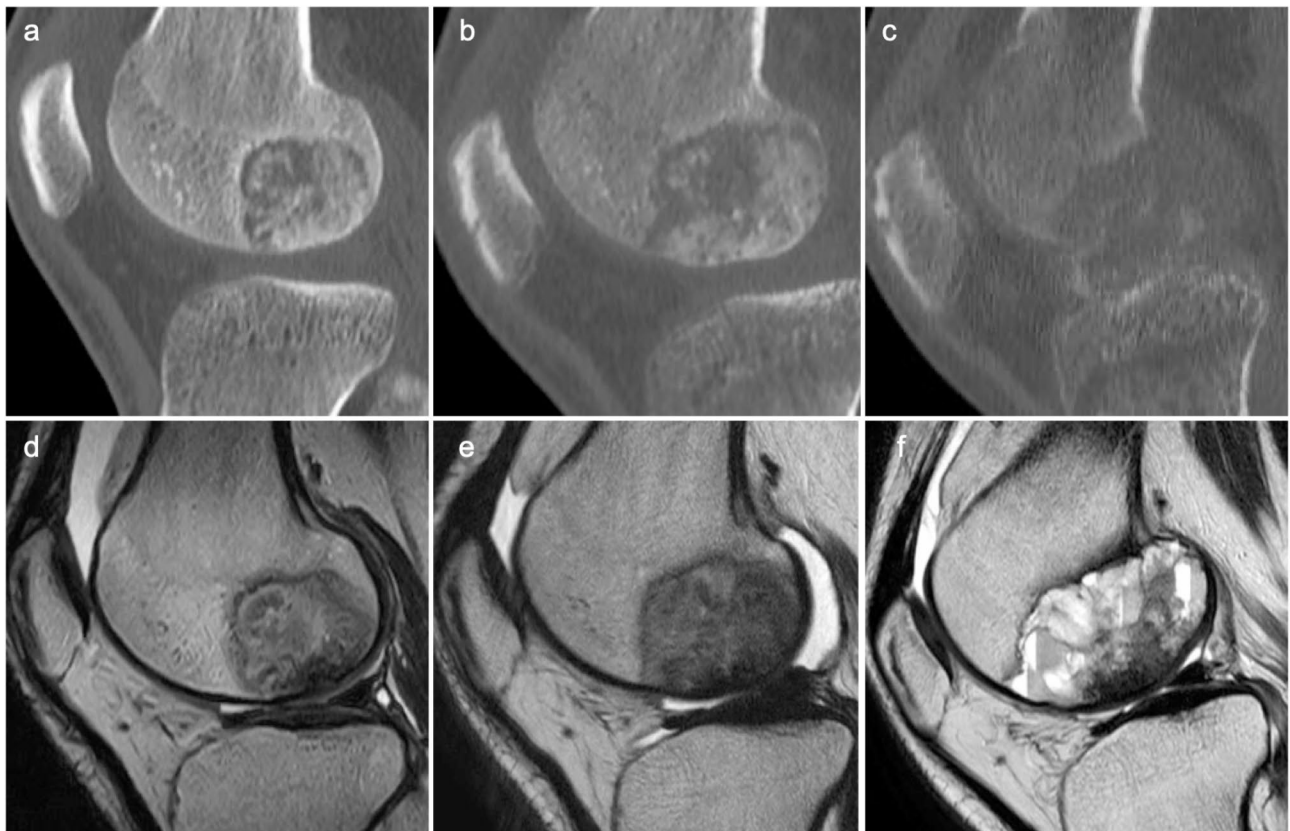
Longitudinal changes in CT and MRI findings in the sagittal plane. a Computed tomography (CT) obtained during the initial visit to the previous hospital, showing a 32-mm lesion adjacent to the remaining epiphyseal scar and trabecular structures in the metaphyseal region. b CT obtained after referral to our hospital, showing an increase in the size of the mass over the epiphyseal scar and partial destruction of the trabecular structure in the metaphyseal region. c CT obtained after preoperative chemotherapy. d T2-weighted image (T2WI) magnetic resonance imaging (MRI) obtained during the initial visit, showing inhomogeneous signal changes. e T2WI MRI obtained at the time of referral to our hospital, 3 weeks after the initial visits, showing changes in signal intensities in the cartilage regions with an increase in synovial fluid. f T2WI MRI obtained after preoperative chemotherapy, showing aneurysmal bone cyst-like changes
